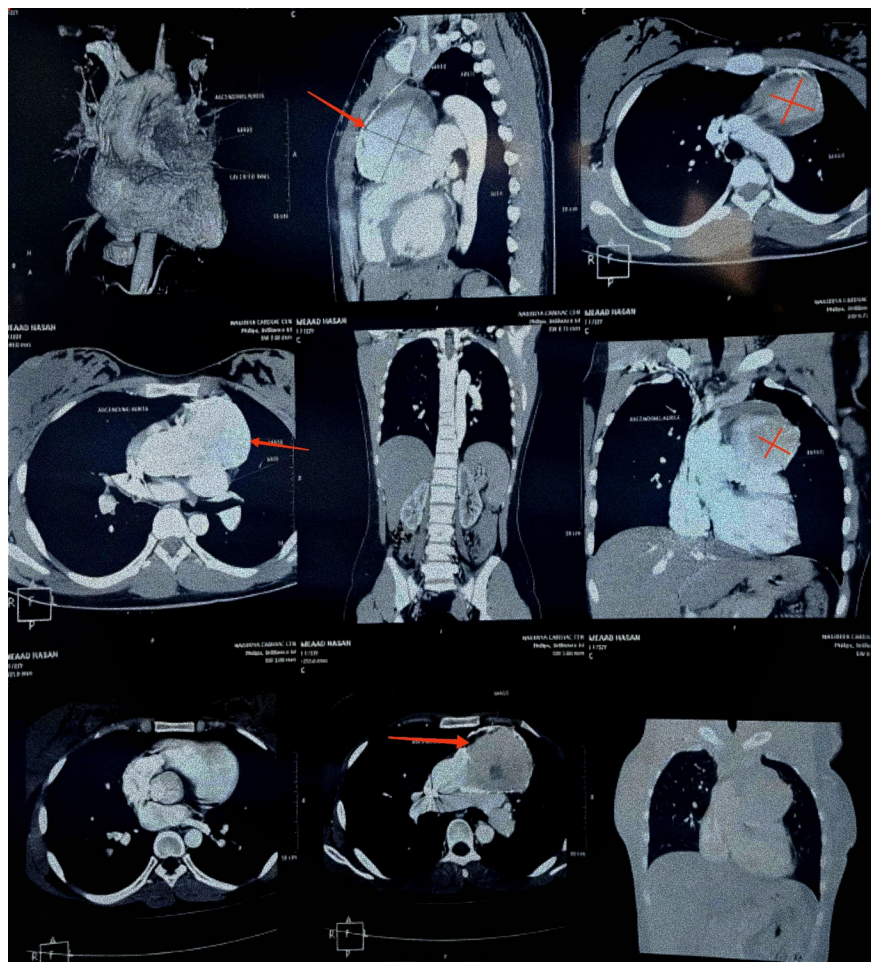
Chest CT angiogram revealing well-defined anterior mediastinal soft tissue density mass lesion of about 84.9x67.2mm seen at aorto-pulmonary window with mass effect compression of the main pulmonary artery and Proximal ascending aorta(red arrows and cross).
